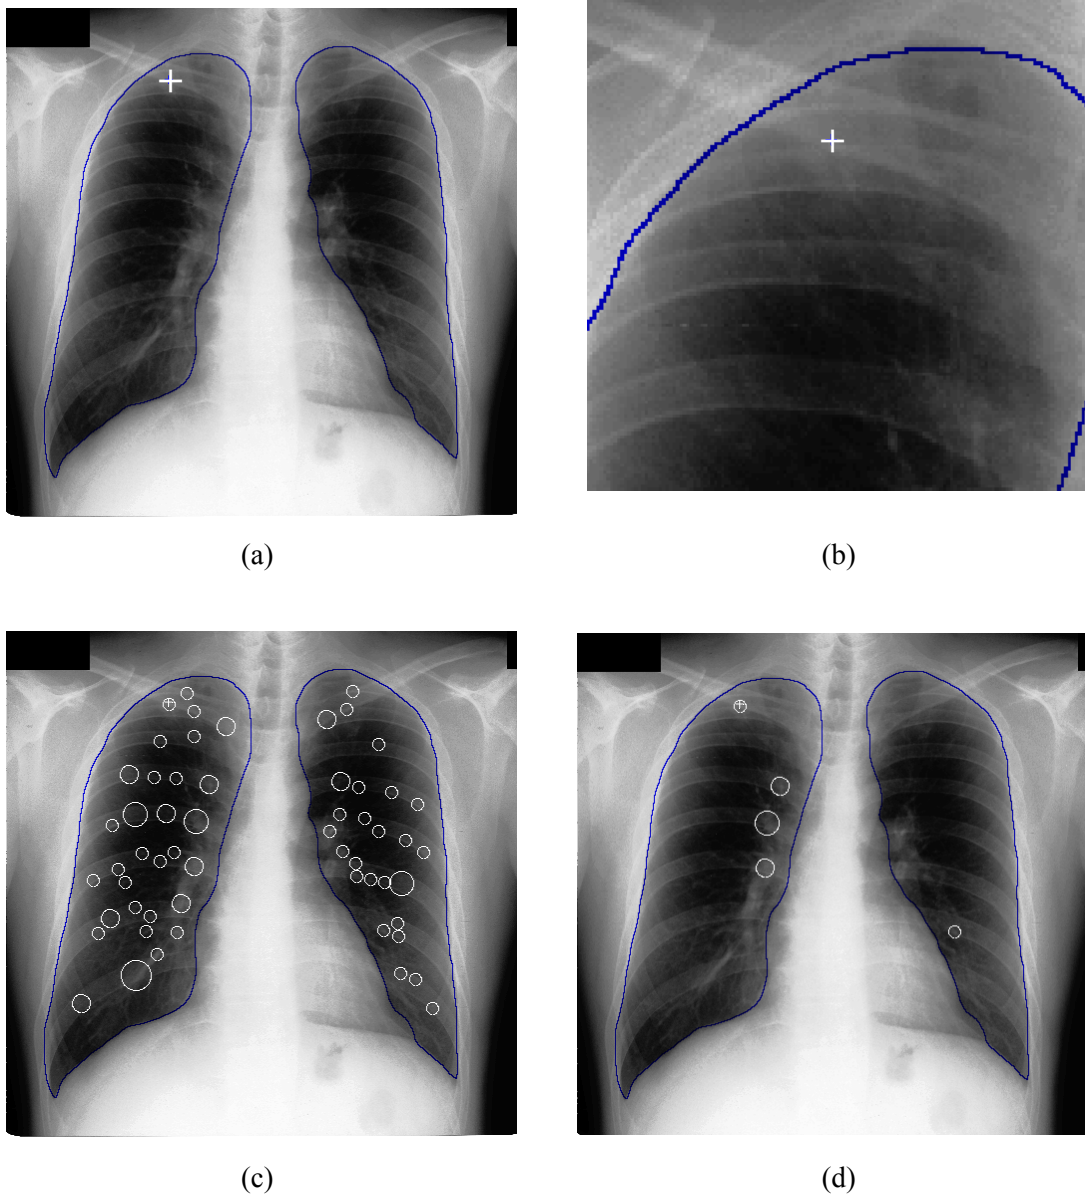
Case JPCLN139: (a) original radiograph; (b) radiograph was zoomed in on the nodule region; (c) after the blob detector; (d) after the classification stage. The Gaussian SVM with $W = 0.75$ and $\sigma_{SVM} = 10$ was used (+: true nodule).
